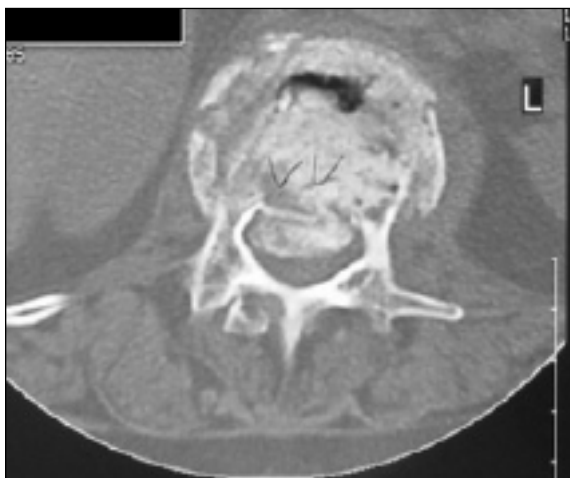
CT-scan revealed significant compromise of canal diameter
